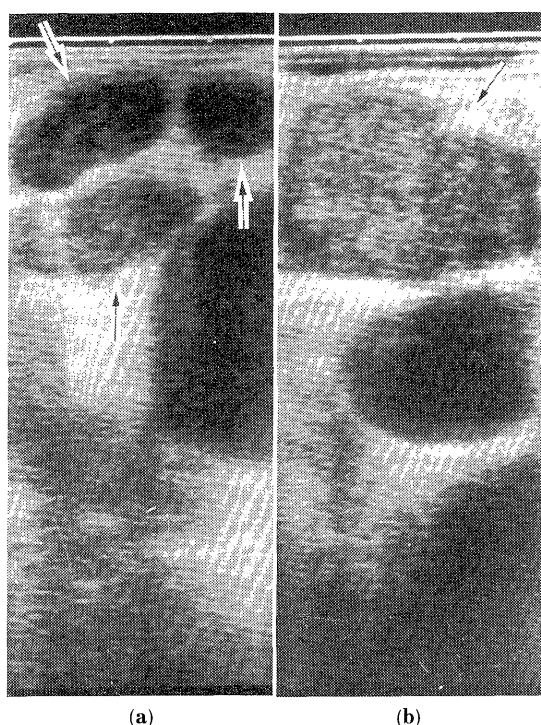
Endoscopic ultrasonograms of metastatic lymph nodes showed sharp and strong echo of boundaries (a), low intensity of internal echo (a), and rough and granular pattern of internal texture (b).
